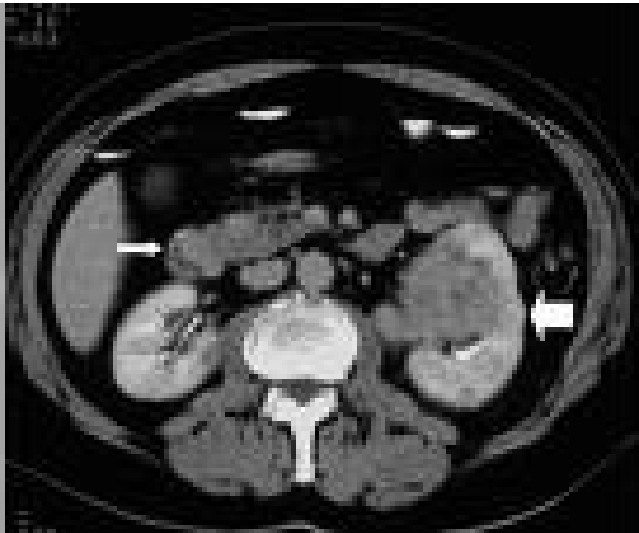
CT Slides Images
